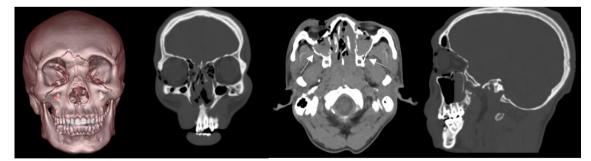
A 23 years old male involved in a motorcycle accident, on CT Scan exam, there are comminuted fracture on the bilateral pterygomaxillary (white arrow), anterior-medial-posterolateral maxillary sinus wall, inferior orbital rim and the nasofrontal junction. On 3D reconstruction image, we can see the pyramid like fracture line, which gives the appearance of floating maxilla or Le Fort fracture type II.
